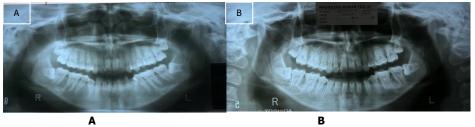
A. Panoramic radiograph before orthodontic treatment; B. Panoramic radiograph after orthodontic treatment.
